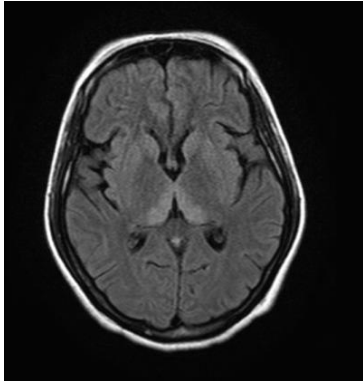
2: MRI Brain(Flair) showed bithalamic, periaqueductal hyperintensities suggestive of wernicke's encephalopathy
